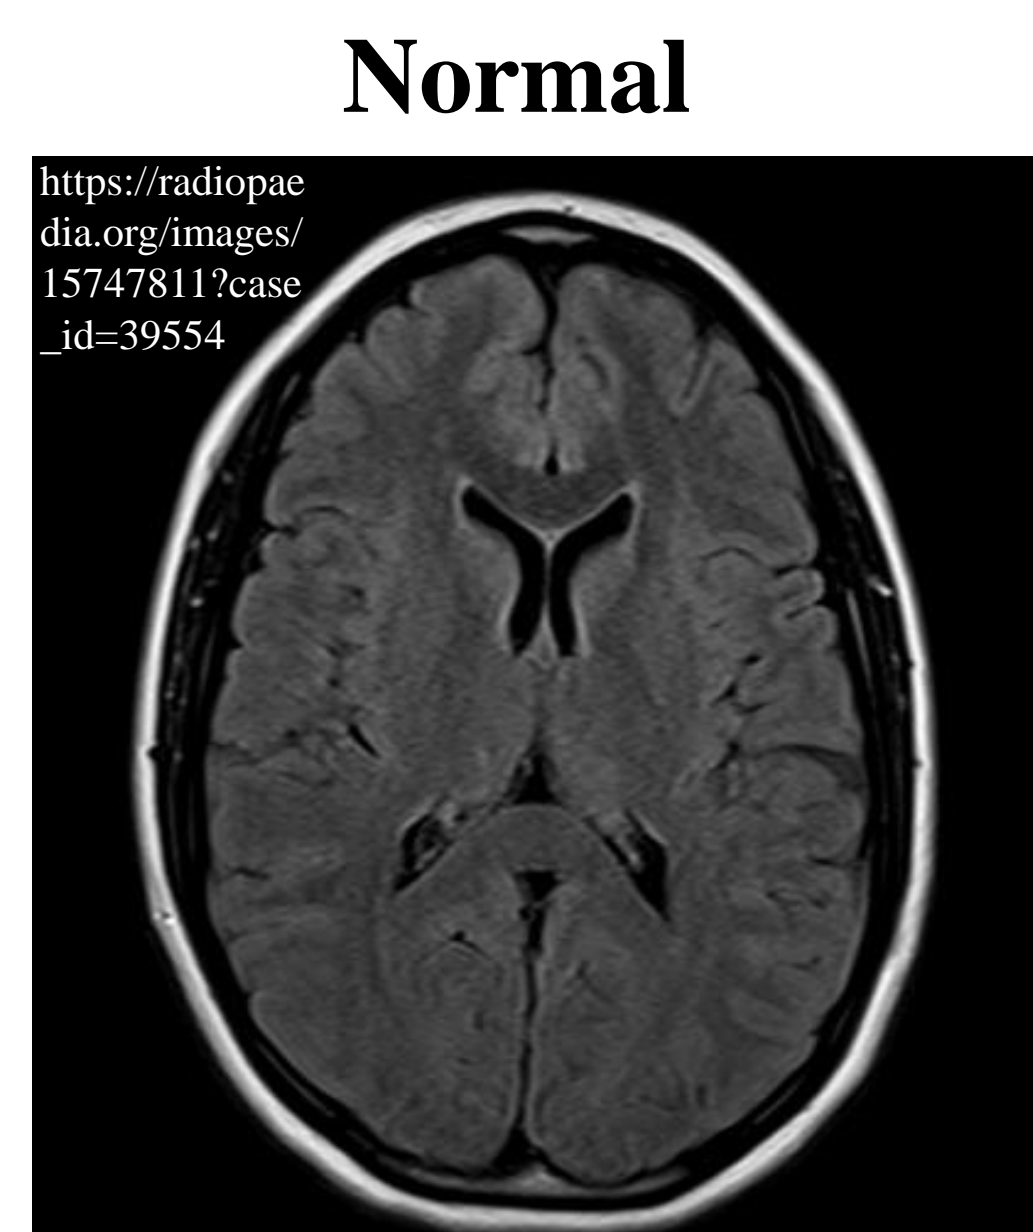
Axial MR image of a normal brain without a glioblastoma
